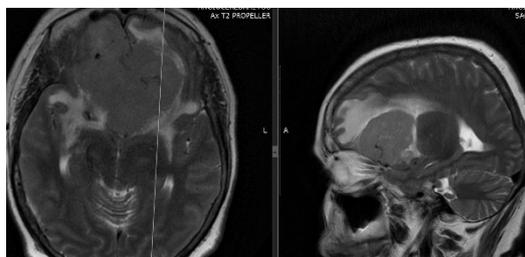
T2 -MRI intratumoral arterial pedicles
